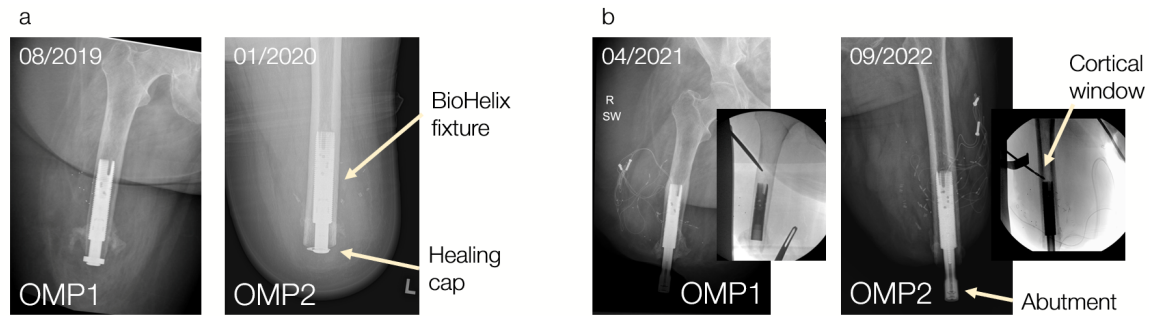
X-ray images following both OMP implementation stages. a) Post stage one with healing cap during acute osseointegration period. b) Post stage two with intramuscular electrodes routed to the titanium abutment through a cortical window. Small round occlusions are tantalum beads placed for muscle position tracking. Longer anisotropic occlusions are surgical staples.
